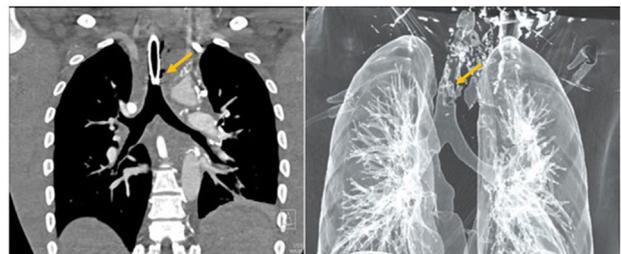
CT scan and 3D reconstruction image.
